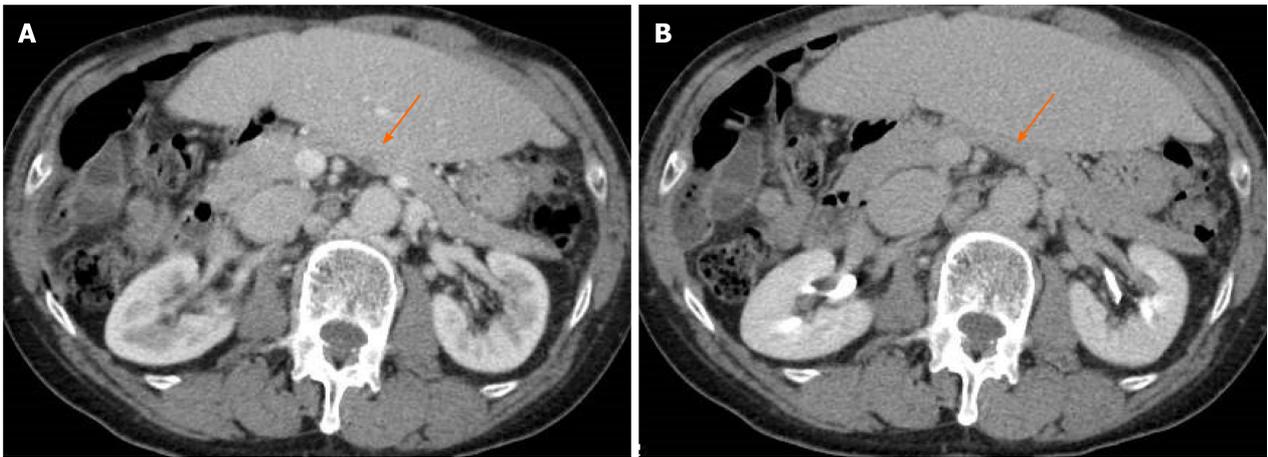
Computed tomography images. A: A 10 mm tumor that was hyperintense with ischemia in the early phase (orange arrowhead); B: A 10 mm tumor that was isodense with pancreatic parenchyma in late phase (orange arrowhead).
